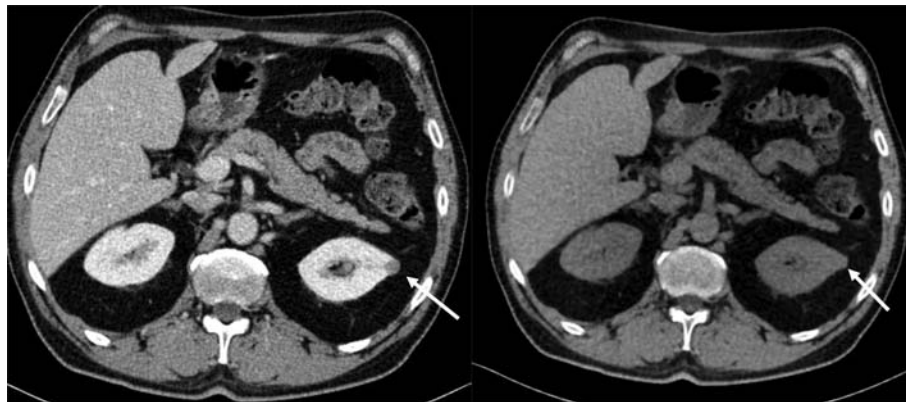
Dual energy CT: CT of the kidneys with i.v. contrast medium (A) shows a small, hypodense lesion in the left kidney (*arrow*). Whether or not there is any contrast uptake in that lesion is crucial for discriminating a neoplasm from for example, a hemorrhagic cyst. Virtual native contrast (VNC) images (B) are retrospectively calculated from the simultaneously acquired Data obtained with different tube voltages, to exclude the attenuation caused by iodine. In this example, the density values on postcontrast and VNC images are identical, so that the suspicion for malignancy is low. Ultrasound confirmed a cyst.
